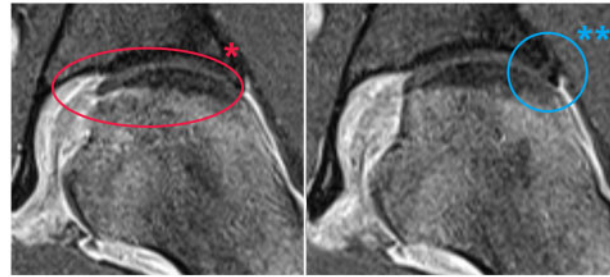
MRI detail (T1 Turbo-Spin-Echo sequence) showing the left hip with *ONFH ARCO III with subchondral collapse (red marking) and labral defect stage III acc. to Beck *et al.* with clear avulsion (blue marking).
